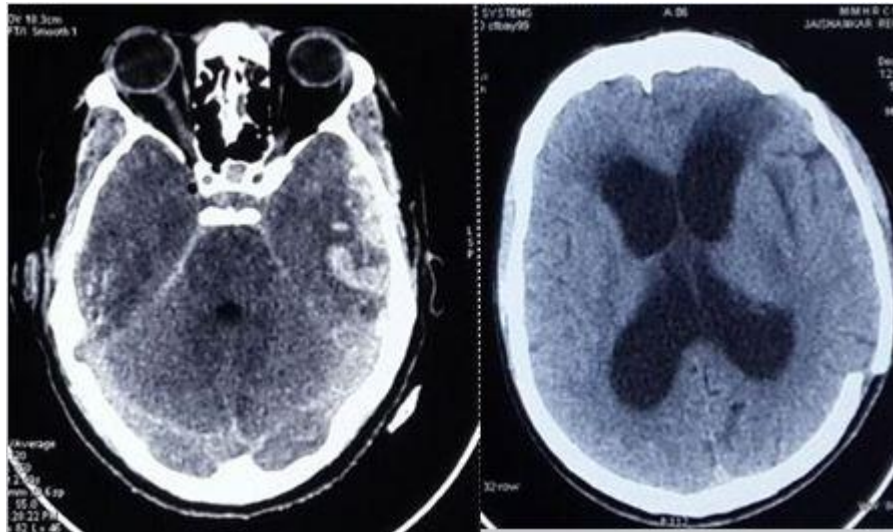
37 years male who underwent craniotomy, CT brain plain axial section at admission (left) and Ct brain done on day 45 showing hydrocephalus (right)
